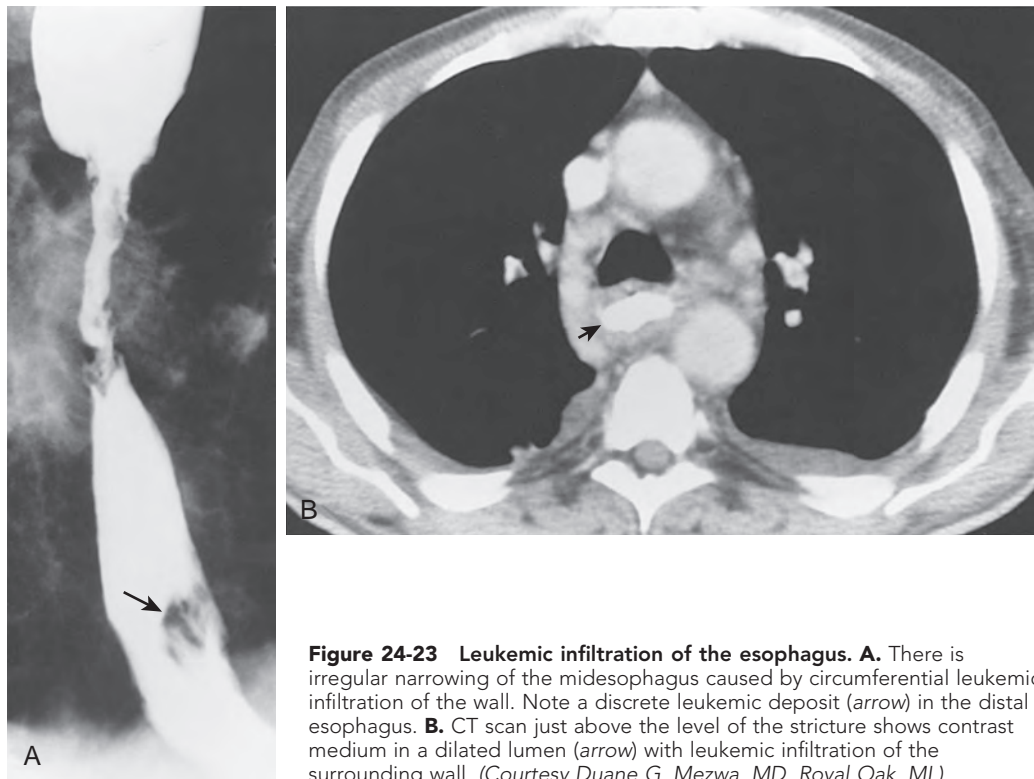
Leukemic infiltration of the esophagus. A. There is irregular narrowing of the midesophagus caused by circumferential leukemic infiltration of the wall. Note a discrete leukemic deposit (arrow) in the distal esophagus. B. CT scan just above the level of the stricture shows contrast medium in a dilated lumen (arrow) with leukemic infiltration of the surrounding wall. (Courtesy Duane G. Mezwa, MD, Royal Oak, MI.)
